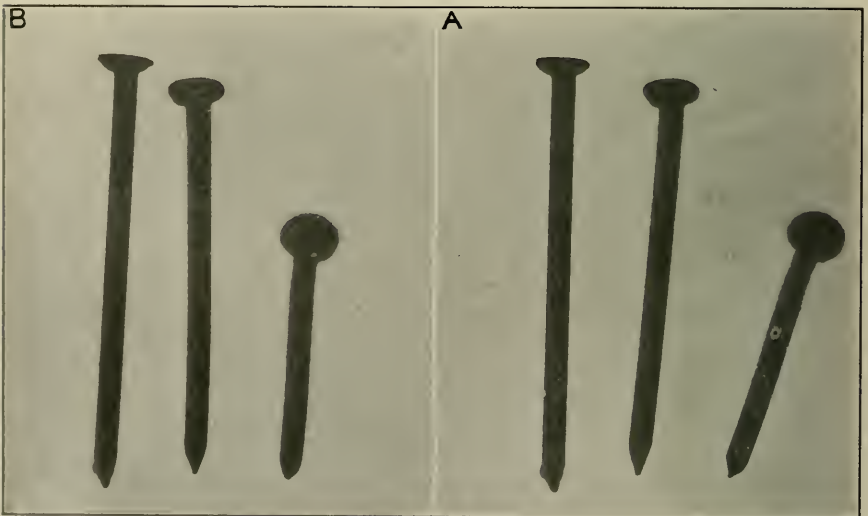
The same as Fig. 341 except that the individual radiographs are interchanged, the right changed to the left side and the left to the right side. Thus in this stereoradiograph the leaning nails lean away from instead of toward the observer.
